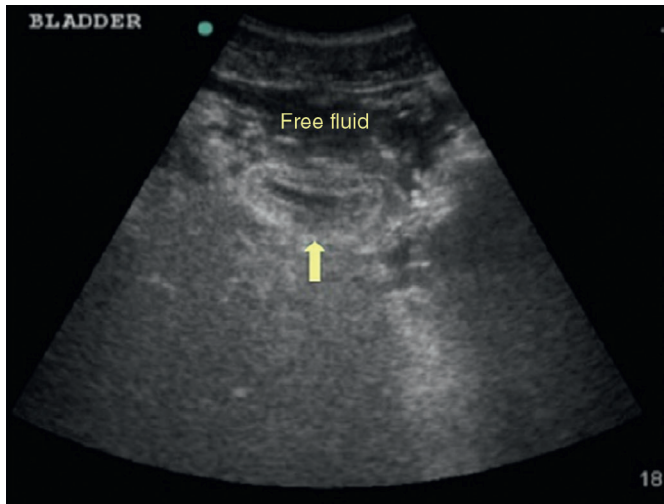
Ultrasound image of bladder rupture. The bladder is contracted, with an irregular bladder wall posteriorly (*arrow*), and free fluid anteriorly. (From Wu TS, Pearson TC, Meiners S, et al: Bedside ultrasound diagnosis of a traumatic bladder rupture. *J Emerg Med* 41:520–523, 2011.)
